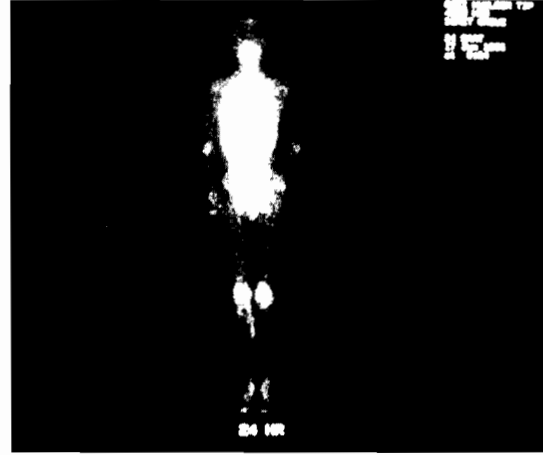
Anterior whole body scintigraphy with Tc-99m HIG in a patient with RA with arthritis of the right and left elbows, wrists, fingers and knees.
